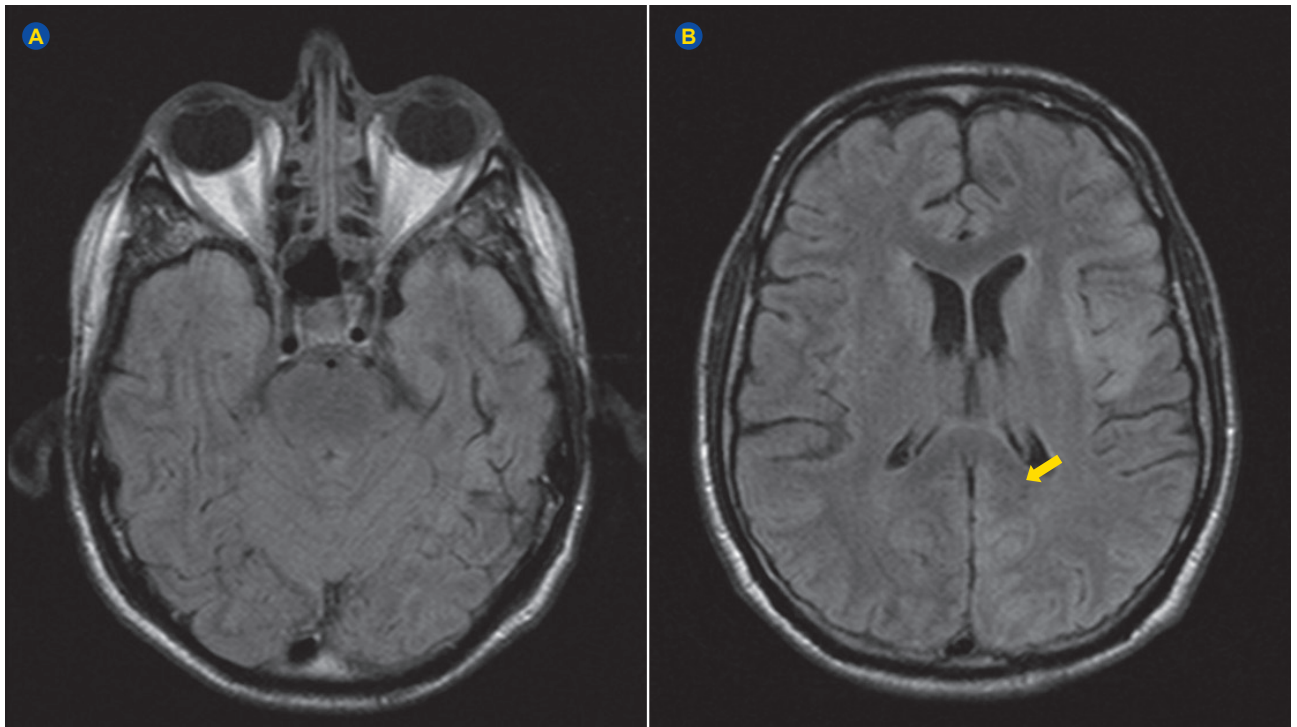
MRI in July 2019 showed no changes on the previous lesion site (medial left temporal lobe) and showed hyperintense T2/FLAIR signal in the left frontoparietal and occipital region
